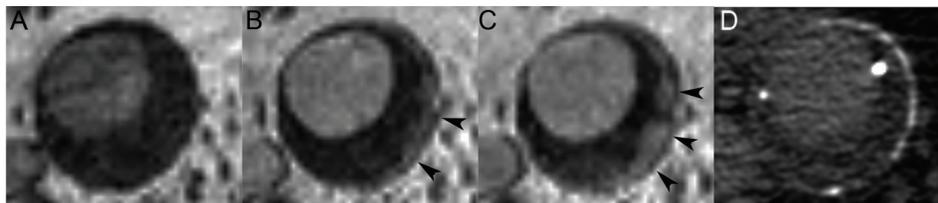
Patient no. 2 in Table 1. Stable aneurysm, 8 years after placement of an Ancure endoprosthesis. Transverse precontrast(A), early postcontrast(B), late postcontrast(C) T1-weighted spin echo image (TR/TE 580ms /15ms) and delayed CT(D) at the same location. B) arrowheads point to region of 'possible endoleak', C) arrowheads point to endoleak, D) no endoleak is visible.
